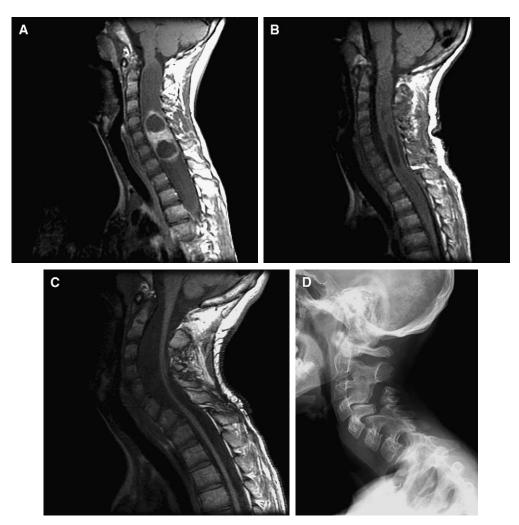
A 10-year-old male patient presented with decreased dexterity and weakness of the right upper extremity. (A) Preoperative T1-weighted MRI scan with contrast revealed a cystic intramedullary cervical cord mass from C5 to C7. A substantial amount of spinal cord edema was present rostral and caudal to the mass. (B) Immediate postoperative T1-weighted MRI scan confirmed a gross total resection, although the spinal cord edema persisted. The pathologic diagnosis was consistent with a ganglioglioma. (C) Postoperative MRI scan obtained 2 years after surgery shows a diminished volume of spinal cord tissue, although neurologic function remained excellent. (D) Despite a laminoplasty being performed at the time of surgery, a gradual lordotic curve in the cervical spine is developing as seen on this plain radiograph of the cervical spine 2 years later.
